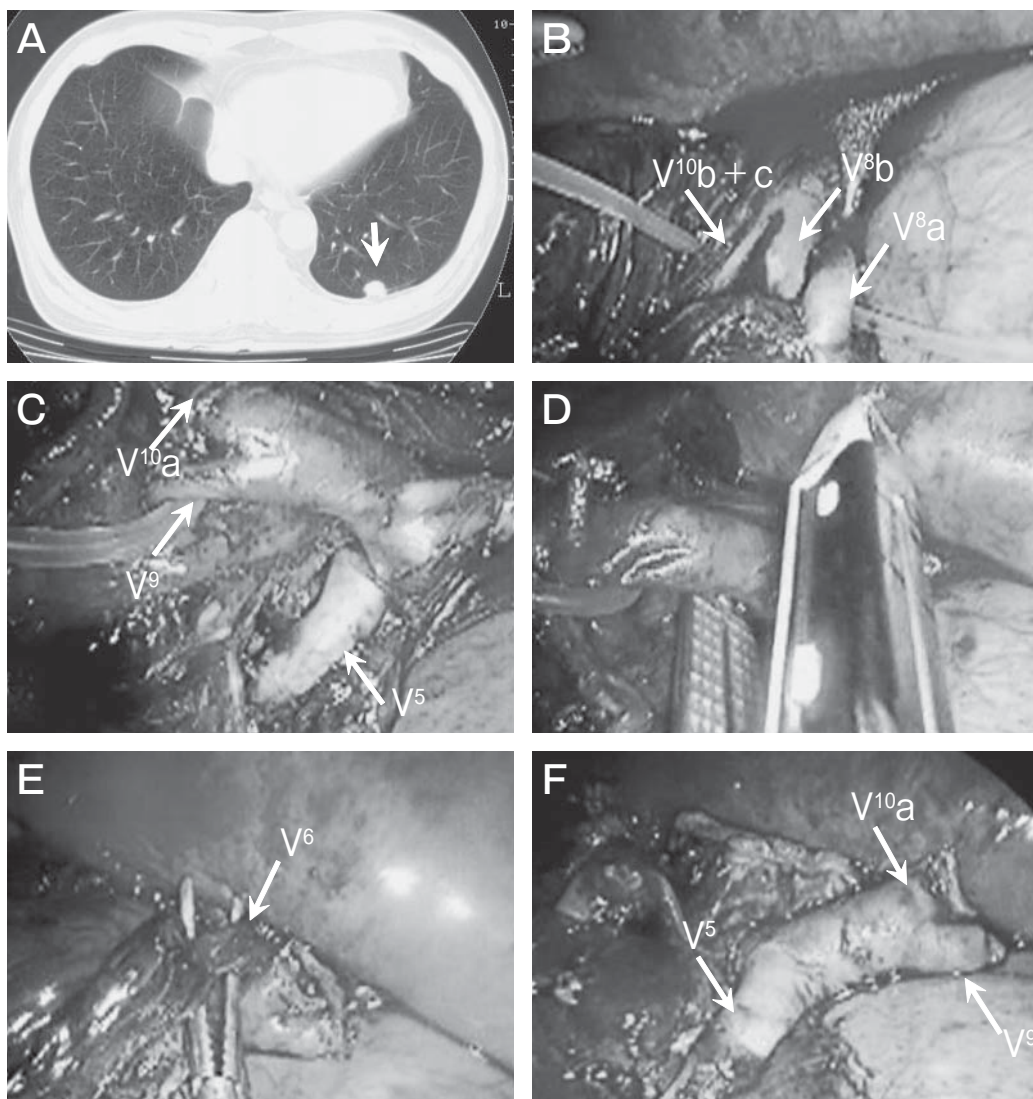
A, Preoperative chest CT shows tumor localization (arrow) in area S¹⁰ of the left lower lobe; B, The branches of left V^{8b} and V^{10b} + c emptying into the dorsal trunk and the additional branch of V^{8a} into the ventral trunk were divided; C, An aberrant ramification from the lingular segment is observed emptying into the proximal ventral trunk, in which V⁹ and V^{10a} empty at the distal level; D, The branch of V⁹ + V^{10a} was divided; E, V⁶ empties into the stem of the dorsal trunk, which was divided; F, The aberrant lingular branch (V⁵) is preserved in the left lower lobectomy. For abbreviations, see Table 1.
